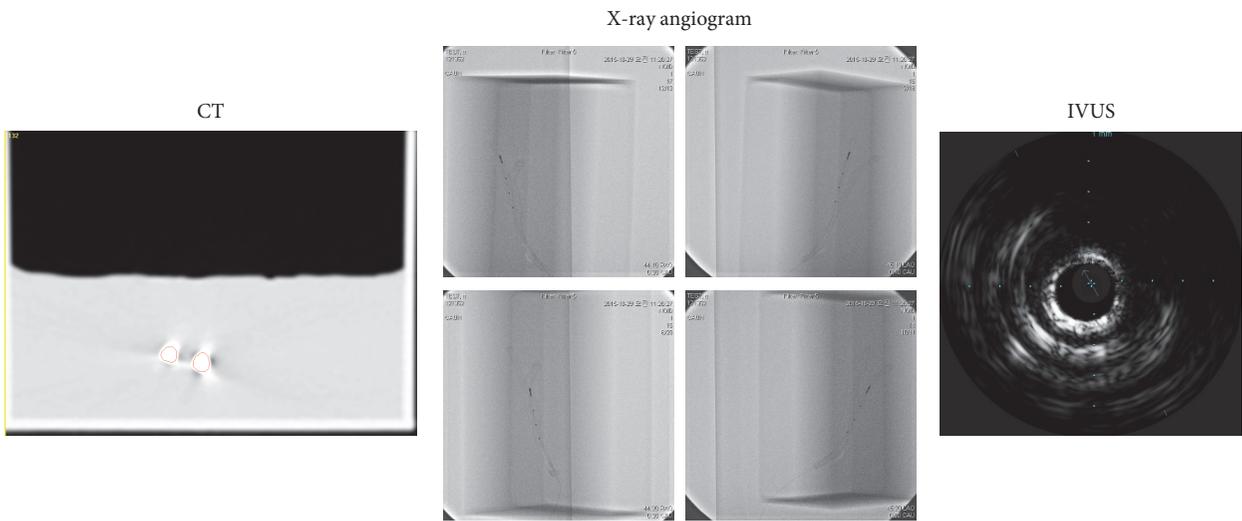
CT, biplane X-ray angiogram, and IVUS images of replica.
